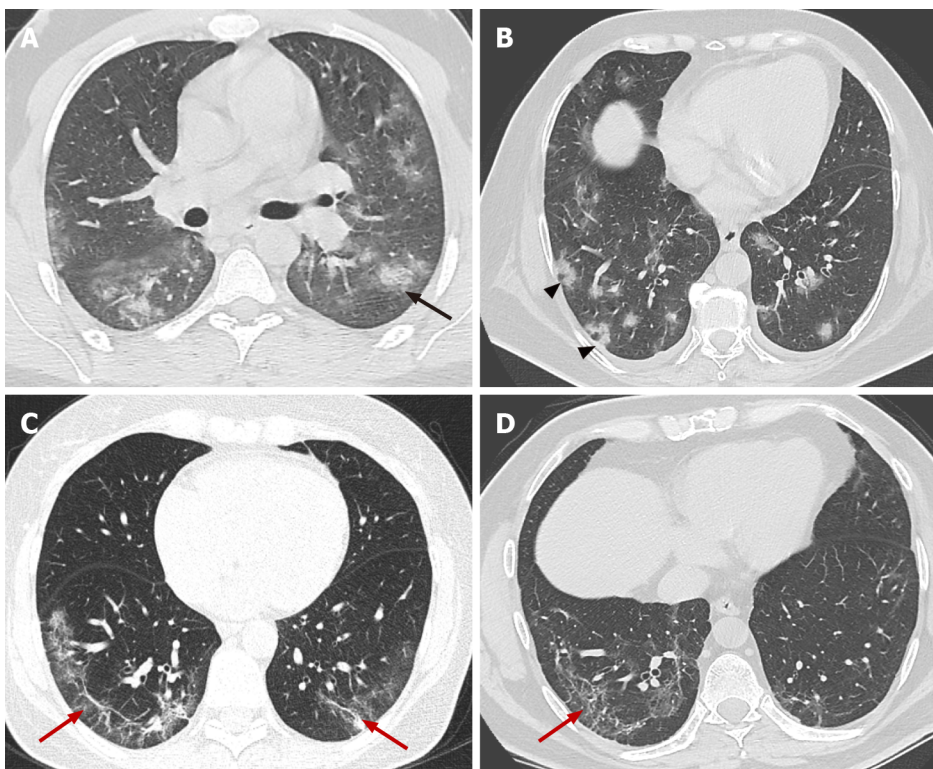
Axial computed tomography images 11 days after symptom onset demonstrate bilateral confluent zones of ground-glass opacities and crazy paving (arrows) with subpleural, predominantly dorsal distribution and with superimposed areas of consolidation (arrowheads), more extensive in the right thoracic half.
